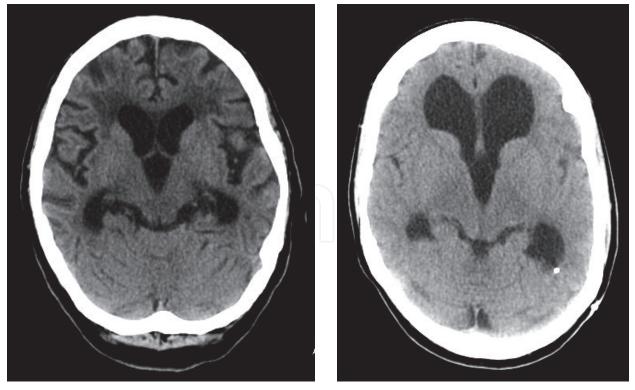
CT in AD on the left and a patient with normotensive hydrocephalus on the right, where a catheter can be seen. CT is helpful to differentiate between AD and other brain conditions.
